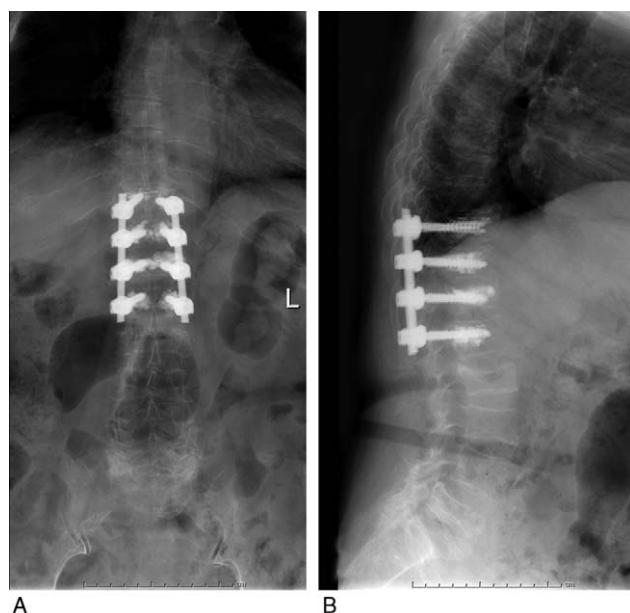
(A and B) Front and lateral of x-rays in 26 months after operation.
